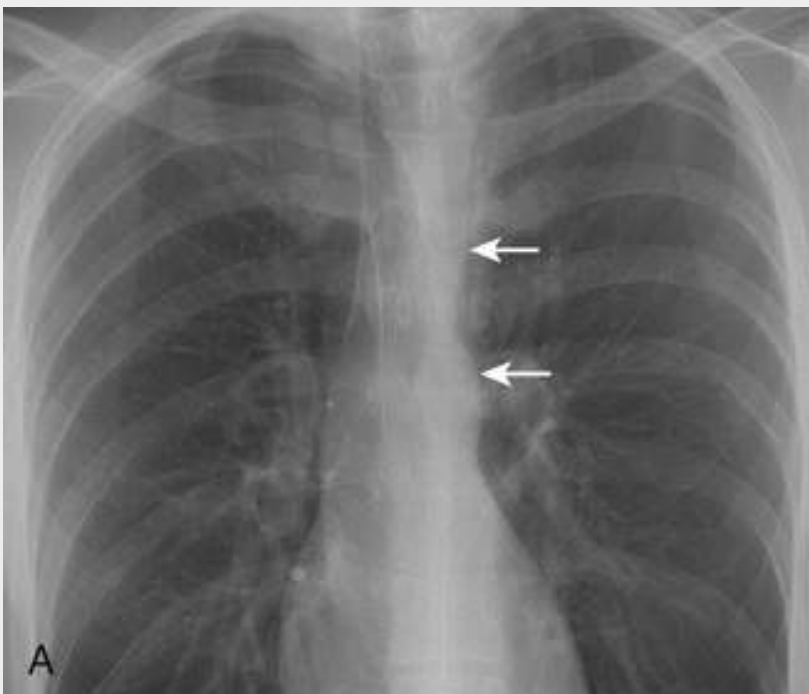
Double aortic arch. Coned-down PA chest radiograph shows right paratracheal bulge representing the larger and higher right aortic arch (*long white arrow*), relative to the smaller and more inferiorly located left arch (*short white arrow*). Note that the trachea is deviated to the left by the right arch (*black arrow*).
